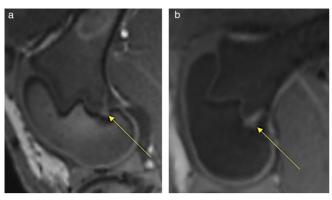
Sagittal slices of T1 MRI image from the operated distal femora. (a) Bone bridge formation, marked with yellow arrow, on MRI T1 in an empty physeal gap. (b) No bone bridge seen on MRI T1 in a fat grafted gap, the fat graft is marked with a yellow arrow.
